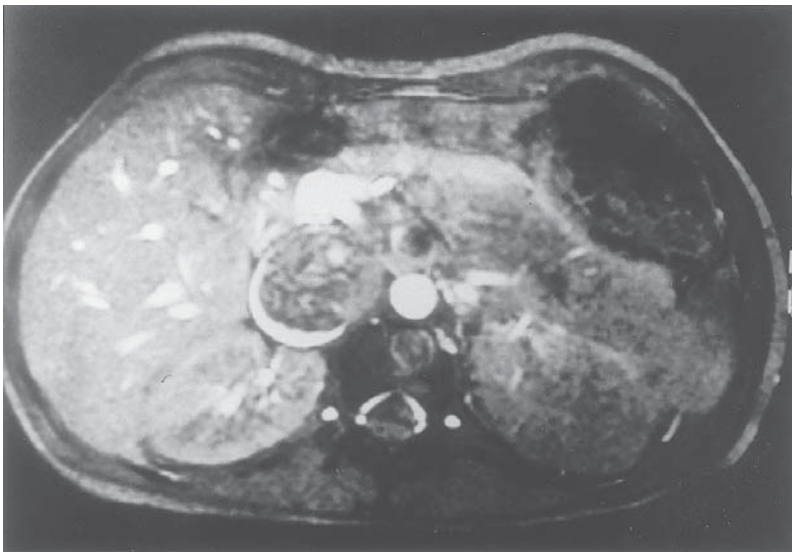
Axial MRI showing left renal mass with large intracaval tumor near upper pole of right kidney.
